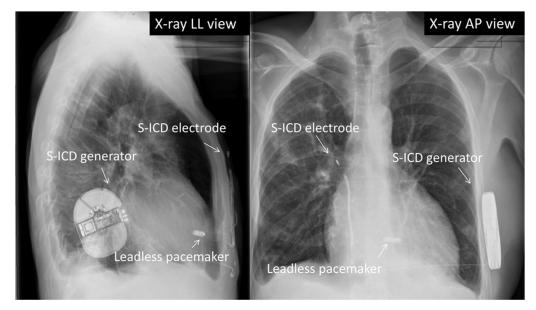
Chest radiograph after the implantation. The images taken in left-lateral (LL) and anteroposterior (AP) view show the position of subcutaneous implantable cardioverter-defibrillator (S-ICD) and leadless pacemaker after the implantation.
